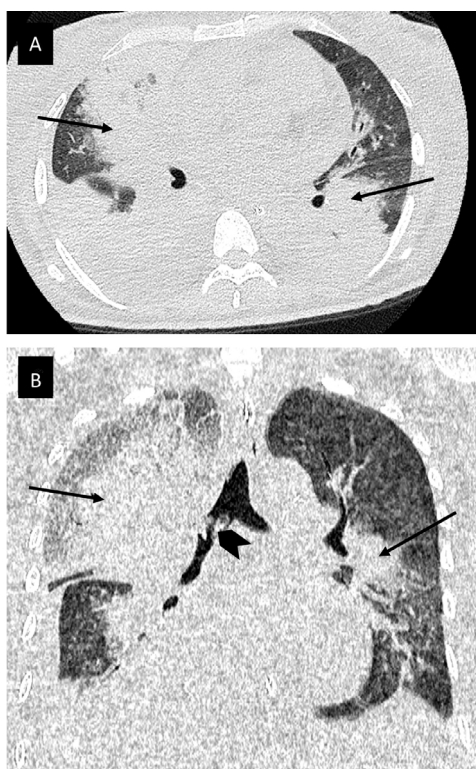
HRCT of thorax in lung window in axial view (A) and coronal view (B) showed bilateral perihilar consolidation (black arrows), right side more than left side.
